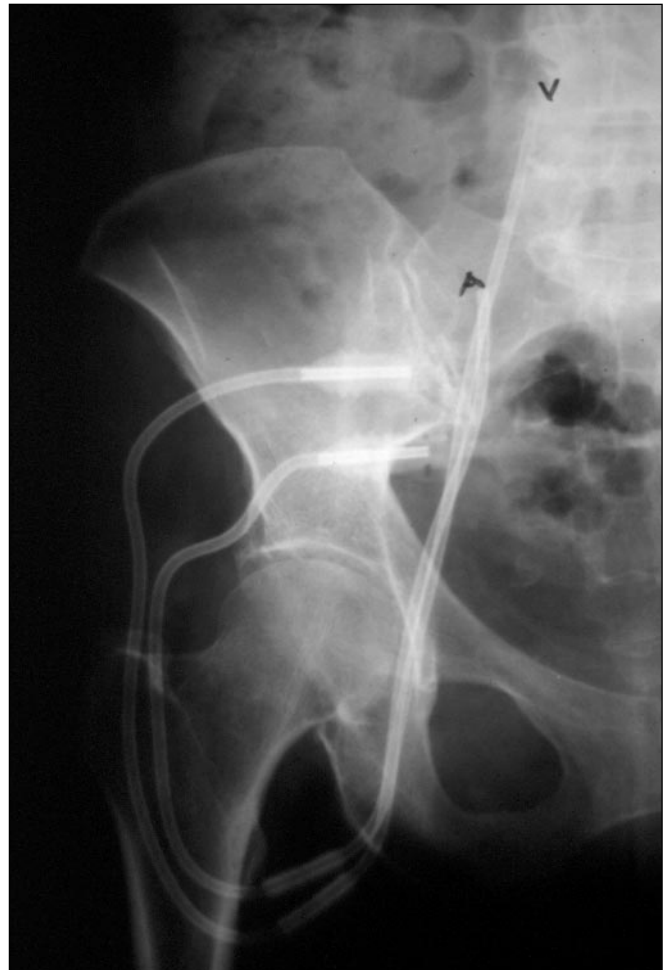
X-ray picture showing a correct positioning, without kinking and with the correct distance, between arterious and venous extremities.*
